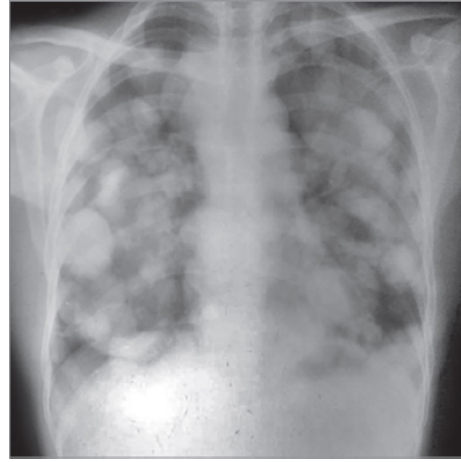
Chest X-ray PA view showing multiple rounded nodular opacities in bilateral lung fields—cannonball metastasis.
